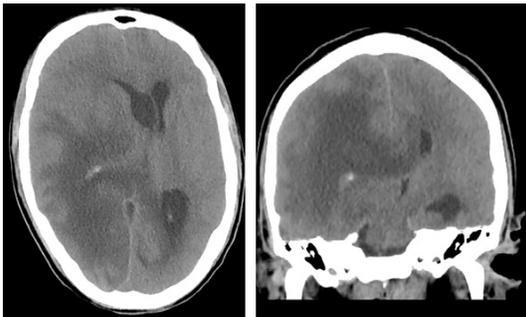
Brain CT at day 52 showing large white matter hypodensity. This finding was likely suggestive of vasogenic edema involving the right parietal, occipital and temporal lobes with significant mass effect and midline shift to the left side of approximately 8.7 cm associated with subfalcine herniation and left lateral ventricle entrapment and enlargement.
